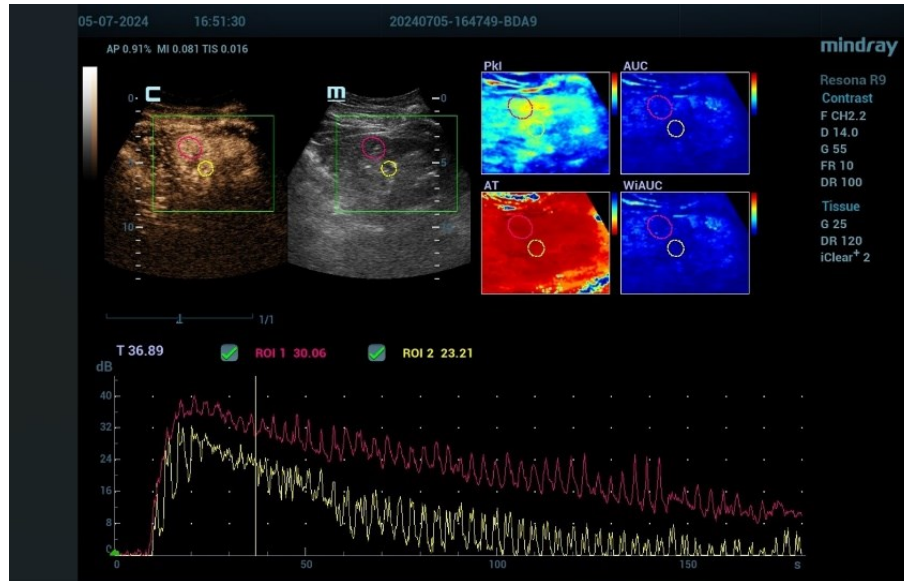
Dynamic contrast enhanced ultrasound of the kidney
